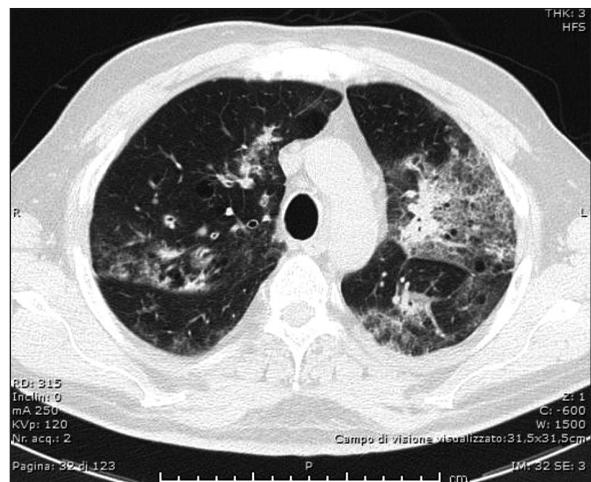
Thoracic CT: multiple nodules and consolidations with air bronchogram and cavitary lesions.
